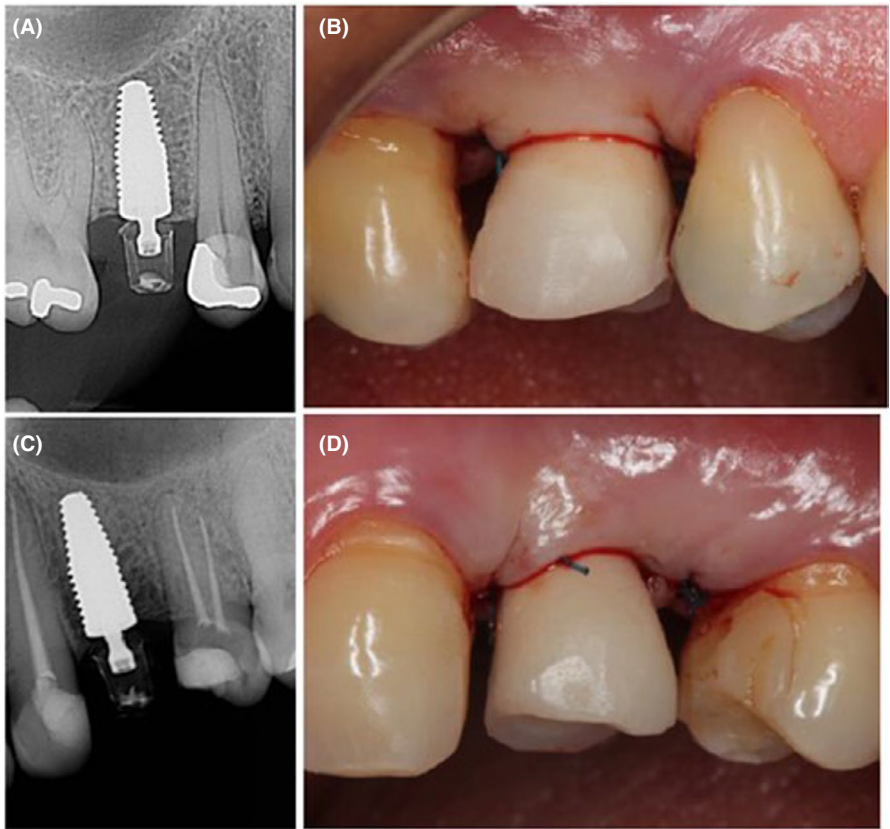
(A–D) Patient 1 postsurgical with immediate loading—periapical x-rays and lateral photographs of regions 15 (A and B) and 24 (C and D)
